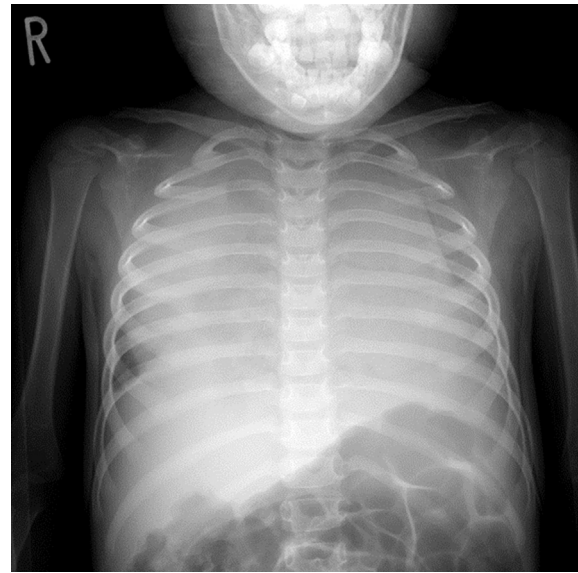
Postmortem anteroposterior chest X-ray. Both lungs exhibited areas of decreased lucency. The cardiac shadow and radiolucent structure of the trachea were not found.
